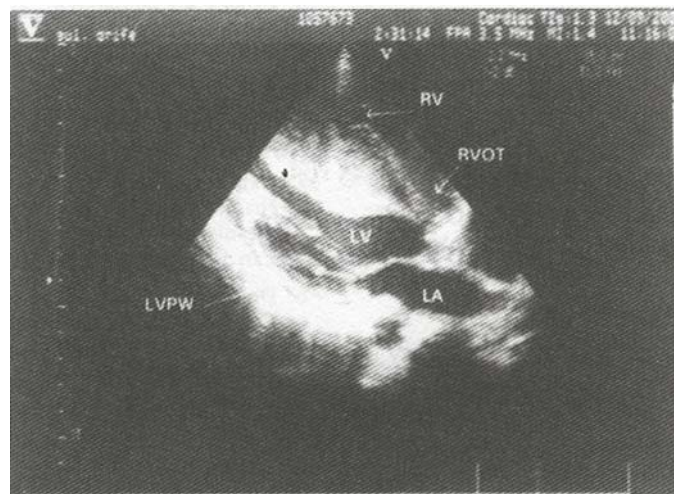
Echocardiographic pre-operative view of asymmetric septal hypertrophy (RV: right ventricle, RVOT: right ventricle outflow tract, LV: left ventricle, LA: left atrium, LVPW: left ventricle posterior wall).
